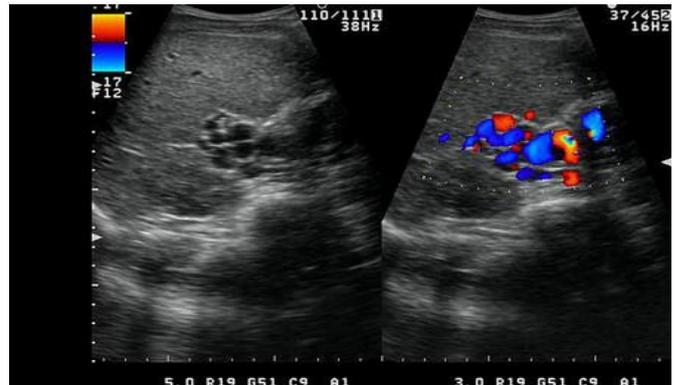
Colour Doppler ultrasound images of two patients show the absence of the main portal vein replacement by multiple serpiginous collaterals suggestive of cavernoma formation. Corresponding greyscale ultrasound images are also given.
